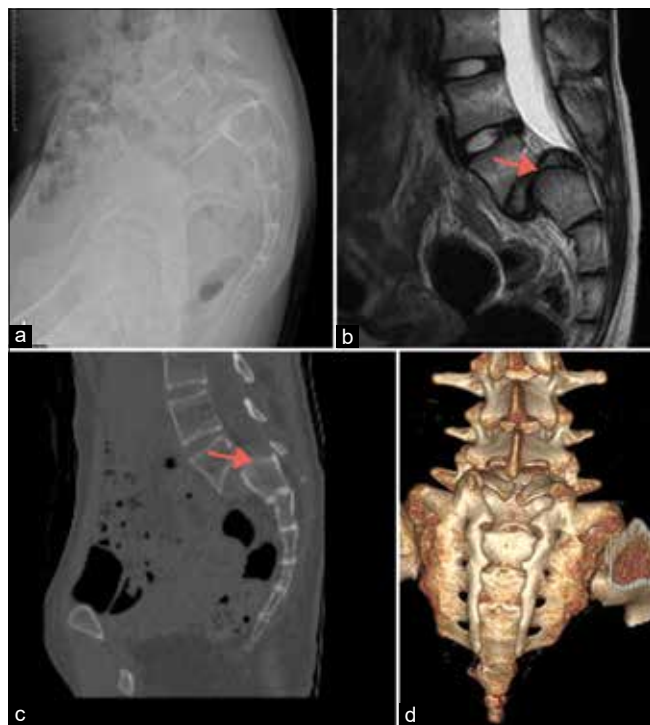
Pre-operative images of the lumbar spine. (a) Lateral radiograph view shows dysplastic type of L5-S1 spondylolisthesis with unbalanced pelvis. (b) Sagittal view magnetic resonance imaging shows a large L5-S1 intervertebral disc (arrow). (c) Sagittal view computed tomography scan shows the sacral dome (arrow). (d) 3D reconstruction of lumbosacral junction shows a complete agenesis of dorsal wall of sacral canal.
